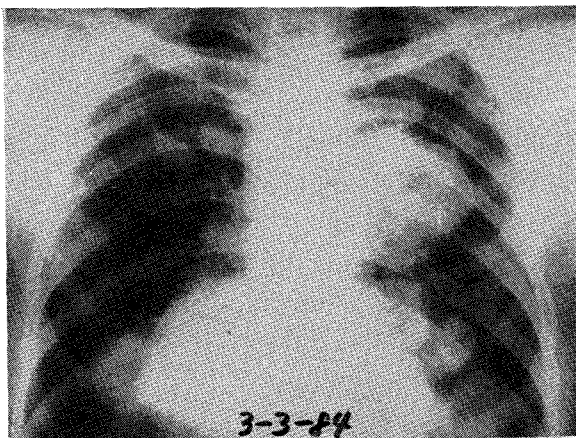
Pre-radiation X-rays of case 4 show multiple variable sized metastases throughout both lung field.
